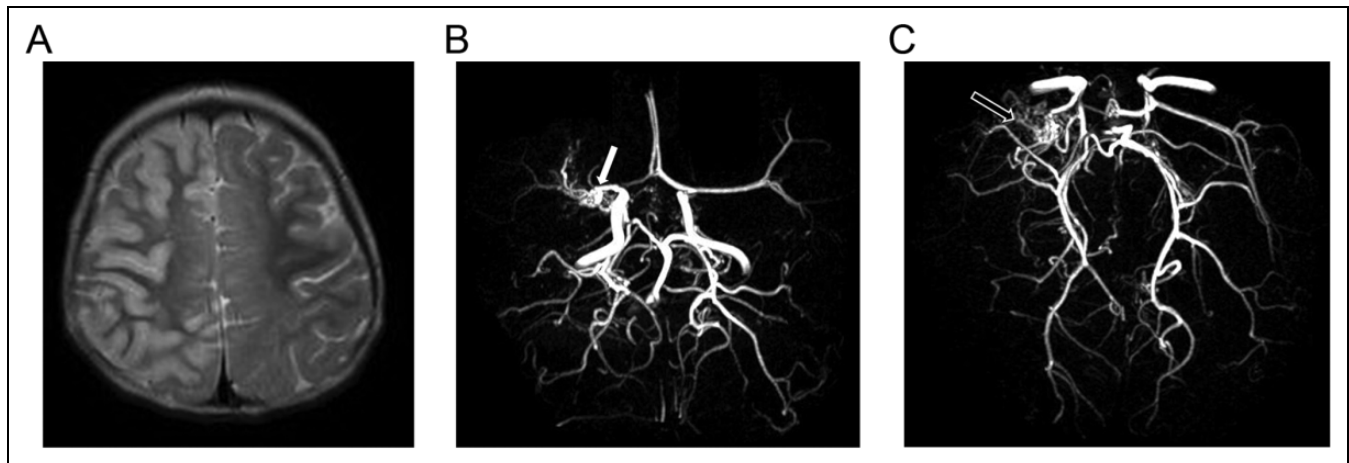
A, T2-weighted magnetic resonance imaging showing hypersignal of the right middle cerebral artery territory. B, Magnetic resonance angiography showing an occlusion of the right middle cerebral artery (white arrow). C, Note a “puff-of-smoke” network of vessels, reminiscent of Moyamoya disease, was also depicted in the territory supplied by right lateral lenticulostriate arteries (black arrow).
